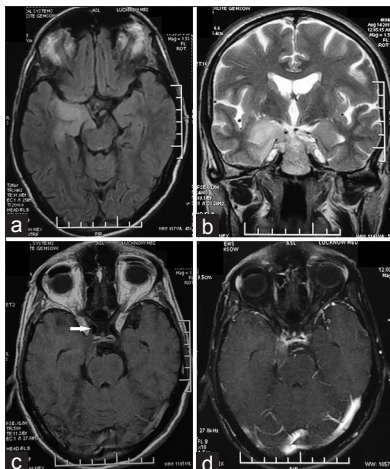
Magnetic resonance imaging brain axial images show an ill-defined lesion hyperintense on T2-fluid attenuation inversion recovery (a) and T2-weighted image (b) and hypointense on the T1-weighted image (c) involving right medial temporal lobe and uncus. The lesion is extending in crural cistern with compression over right cerebral peduncle. Mild enhancement is noted on the postcontrast T1-weighted image. (d) Extension in the cavernous sign is also noted (arrow)
